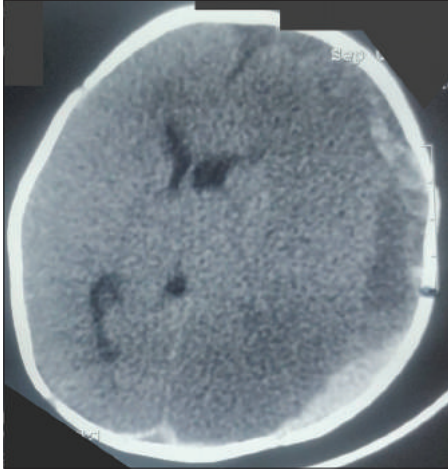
Plain CT head in an infant with Vitamin K deficiency, large subdural bleed on the left side (black arrow, note the separation of serum and clot giving two density appearances of the bleed), with secondary ischemic changes and midline shift. The baby had presented with pallor, coma, and bulging non-pulsatile anterior fontanelle.
